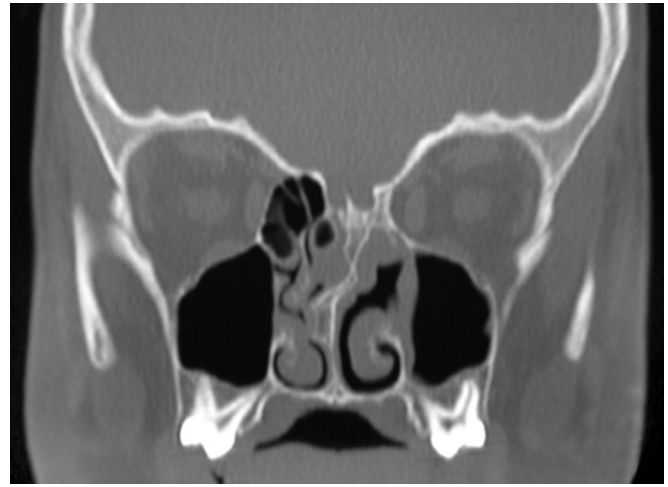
Coronal computed tomography demonstrating encephalocele with bony defect at cribriform plate.
